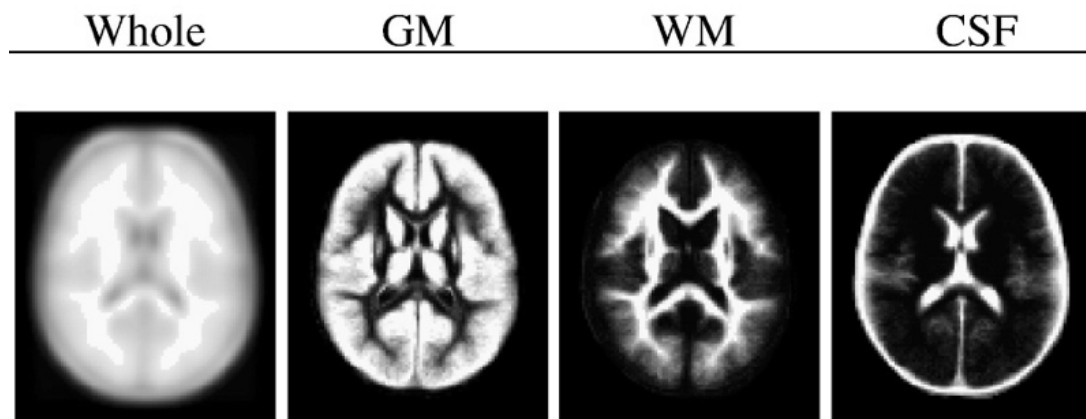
T₁-weighted averaged MRI data for infants aged 9-15 months produced by Altaye et al. Far left: T₁-weighted head intensity template. Centre left: grey matter tissue probability map. Centre right: white matter tissue probability map. Far right: CSF tissue probability map. Figure taken from Altaye et al. (2008). Reprinted with permission from Elsevier⁷.
